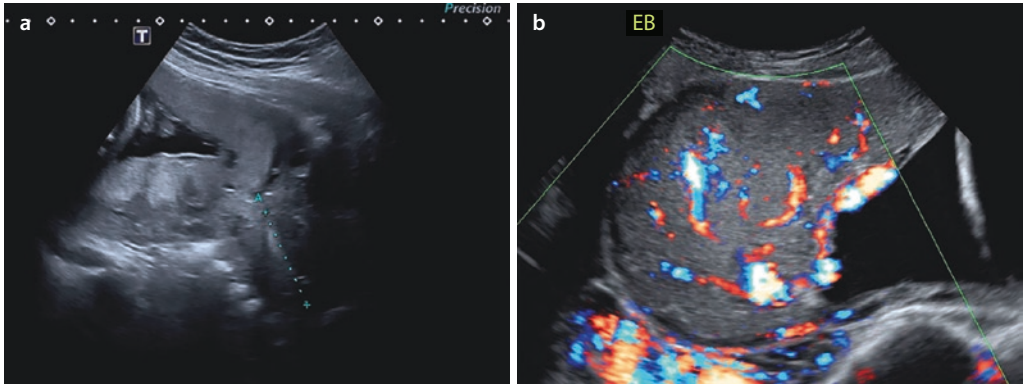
Placenta praevia. a Sagittal section, distance A indicates cervical length (B-scan). b Sagittal section with increased vascularization, covering the entire anterior wall (B-scan with color Doppler)
